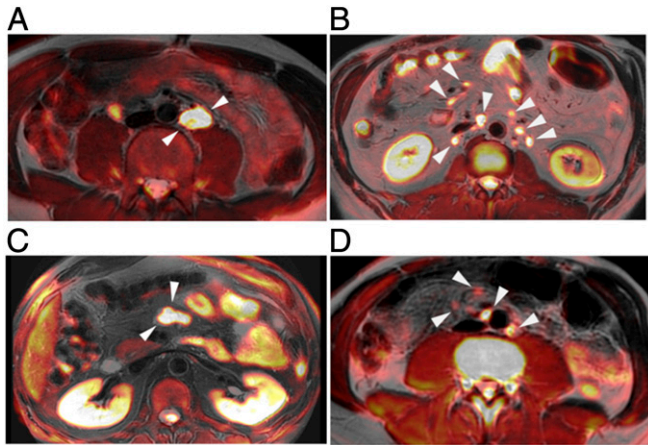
MRI detects lymph nodes in some areas of the abdomen in transplanted SCID patients. Fusion imaging of T2-weighted sequences and DWI in male patient (P6) (A and C) and controls (B and D). Some large isolated lymph formations are visualized in the retroperitoneal region and in the celio-mesenteric areas in a 27-y-old patient (P6) and a 44-y-old (C, arrowheads) (P1), respectively. In controls, lymph nodes are more numerous and smaller-sized, visible both intra- and retroperitoneally (B and D, arrowheads).
